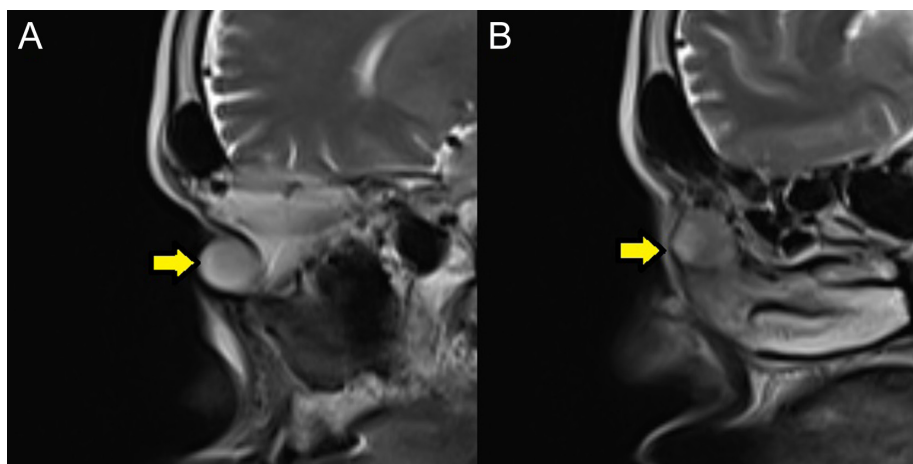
Sagittal plane T2-weighted MR images showing the lesion with well-defined borders (yellow arrows).
